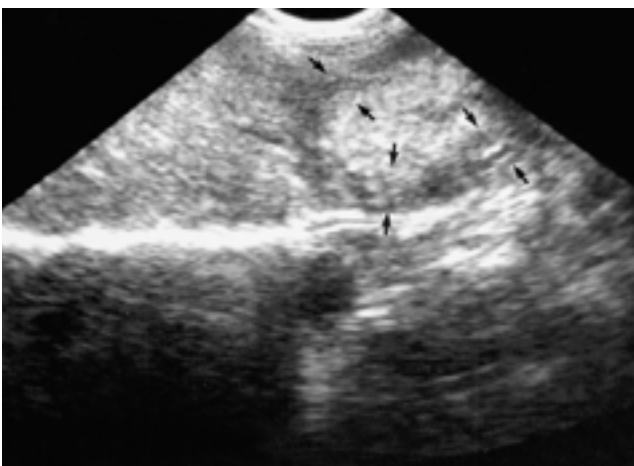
A 62-year-old man having biopsy-proven peripheral cholangiocarcinoma in the left lobe of the liver. Ultrasonogram shows a 7 cm, lobulated, heterogeneous, hyperechoic mass in lateral segment of the left lobe of the liver. Thick and mixed type of halo was seen at the peripheral portion of the mass.
